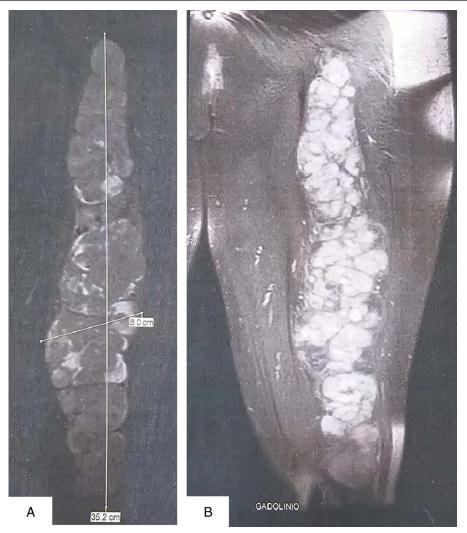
(A) Tumor measurements 35.2 cm × 8 cm (B) MRI postcontrast enhancement, multiple nodules, typical of plexiform Schwannomatosis.
